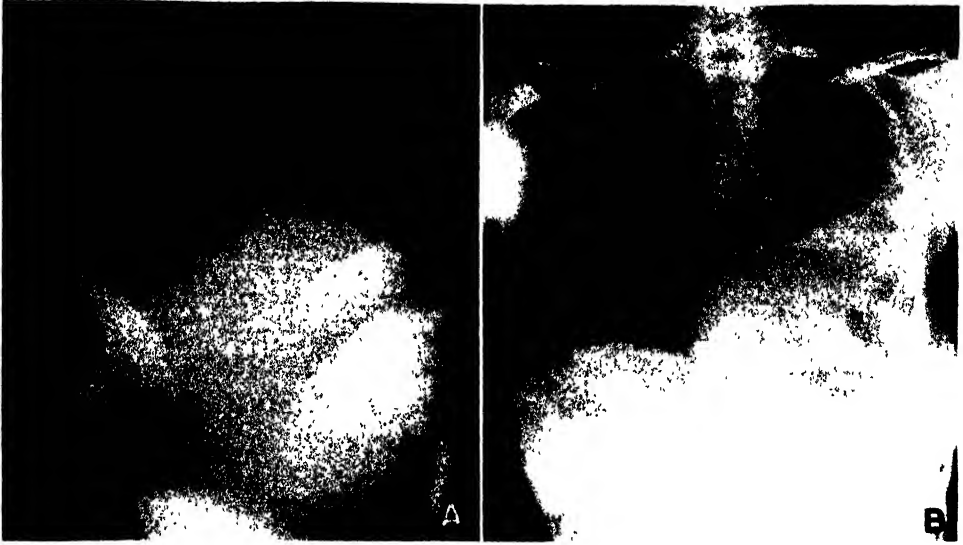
Actinomycosis of the chest as shown by roentgenograms. *A*, infiltration in right lower lobe with associated pleural effusion; generalized cardiac enlargement. In the lateral view, the patchy infiltration was seen to occupy the right middle and lower lobes. *B*, symmetrical thorax with smooth high diaphragm on the right. The diaphragm on the left is in average position but shows tenting. Both costophrenic angles are clear. Size and shape of heart shadow are not unusual. The right lower lobe is reduced in volume and the lung markings are prominent in this region. The dense shadow in the hilar region is probably due to an enlarged lymph node. In the third left interspace, a uniform density is noted which gradually fades out toward the second anterior interspace. The first interspace is entirely clear. There is a veil-like density throughout the lower left lung field. In the lateral film, a dense round shadow, probably an enlarged lymph node, was seen in the hilar region.
